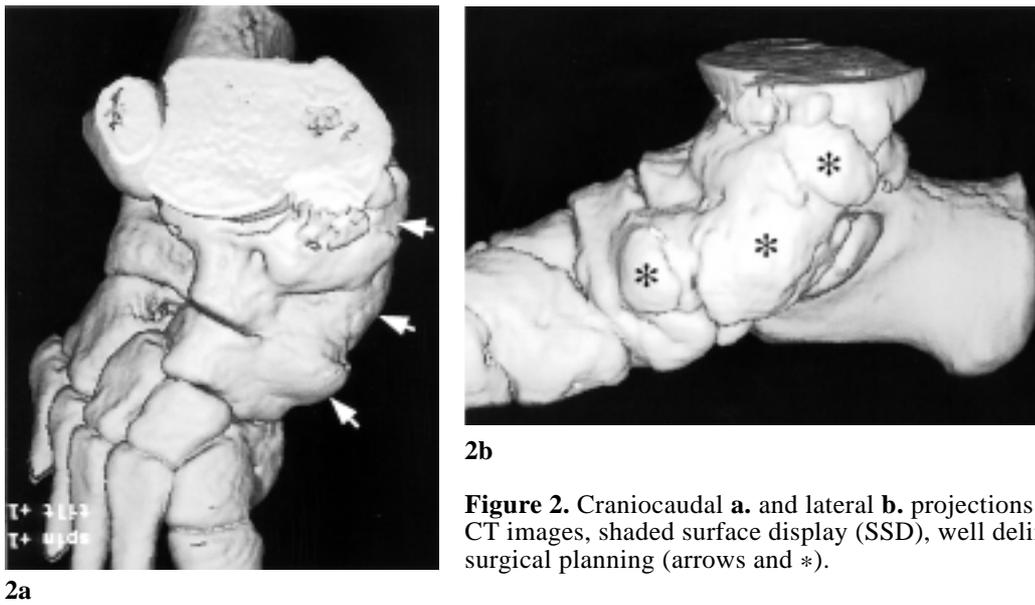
Craniocaudal a. and lateral b. projections of the 3D reconstructed CT images, shaded surface display (SSD), well delineate the lesion for surgical planning (arrows and *).
